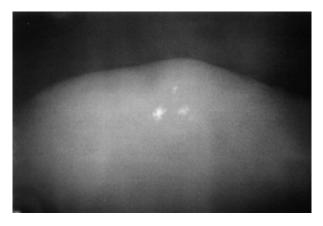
Presence of the remaining tooth fragment in the lower lip revealed by periapical radiograph.
